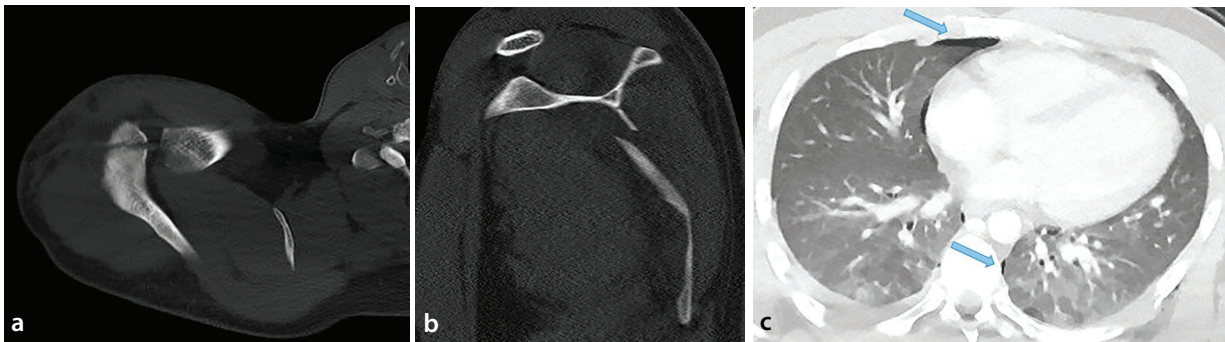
A 23-year-old Afghan man fell from construction scaffolding. (a, b) Computed tomography scans revealed right scapula and acromion fractures, along with (c) bilateral pneumothorax (arrow).
